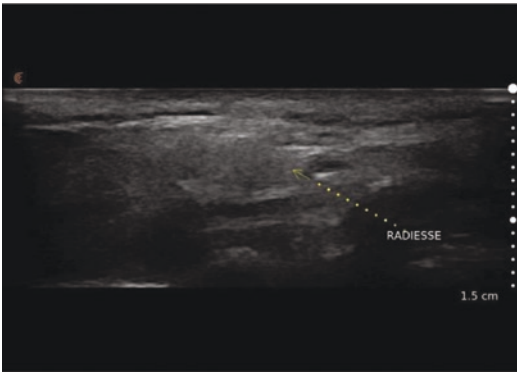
Grayscale ultrasound image of the cheek after calcium hydroxyapatite filler (Radiesse®) injection. The diffuse hyperechoic nature of the filler is seen
